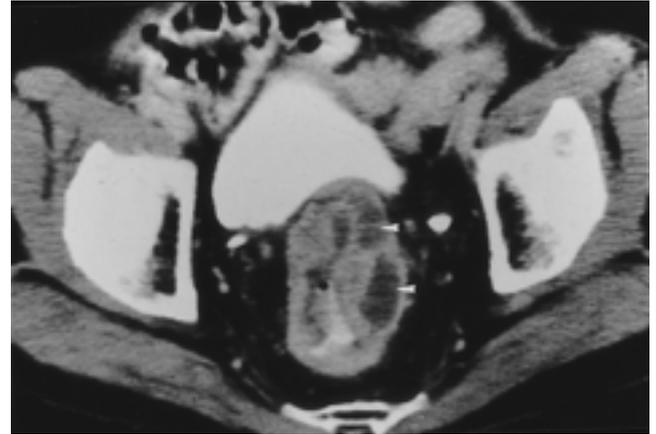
A 61-year-old man with mucinous carcinoma of circumferential/polypoid shape. Contrast-enhanced CT shows circumferential wall thickening of the rectum with heterogeneous enhancing mass containing multifocal hypoattenuated mucin pool (arrowheads).
